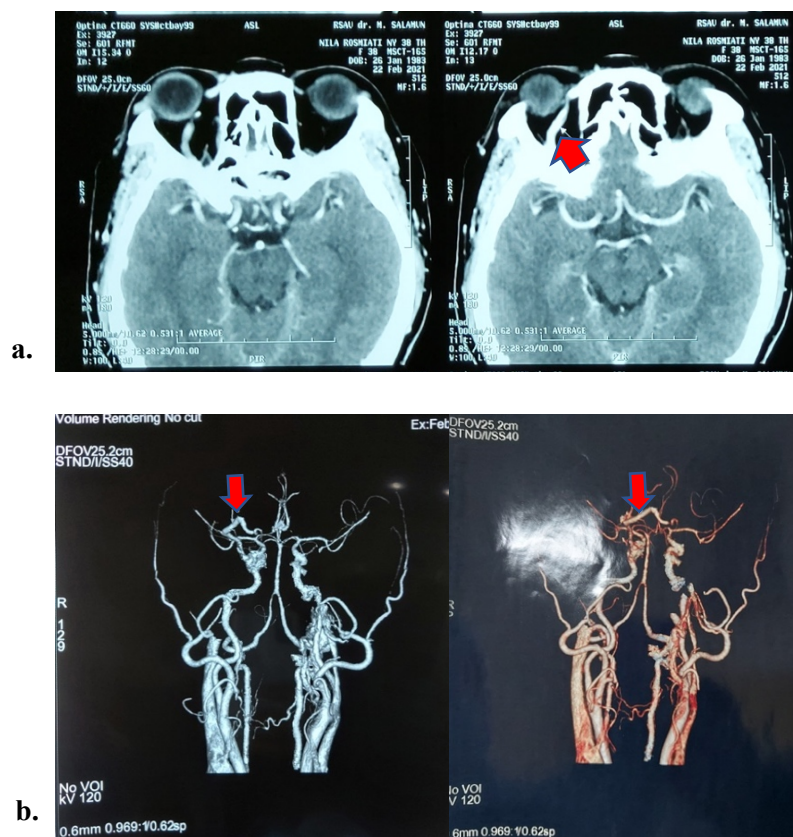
Contrast Enhanced CT Scan Brain-Orbita (a) and CT Angiography (b) of The Patient
